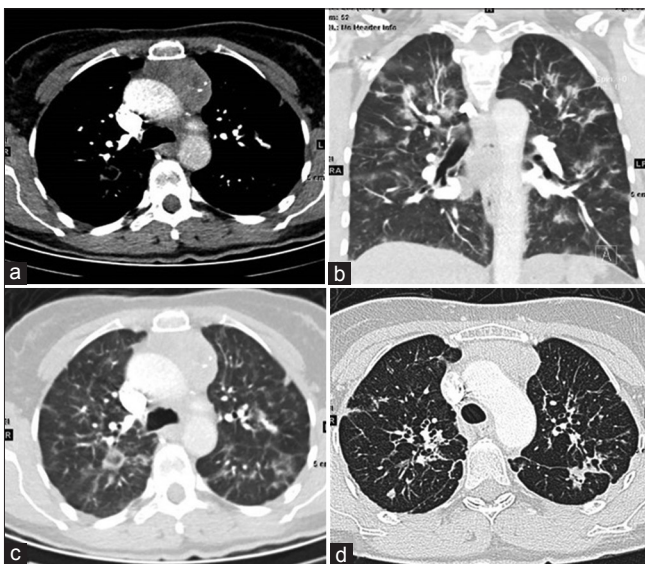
High-resolution computed tomography of the chest. (a) The mediastinal window showed large anterior mediastinal mass. (b and c) Coronal and axial lung view showing evidence of bronchiolitis with presence small airway bronchiolar wall thickening suggestive of mild bronchiectasis associated with peribronchiolar nodularity along with air trapping. It is associated with variable size nodular infiltrate. (d) High-resolution computed tomography in May 2017 showed progression of peribronchial fibrotic streaks
